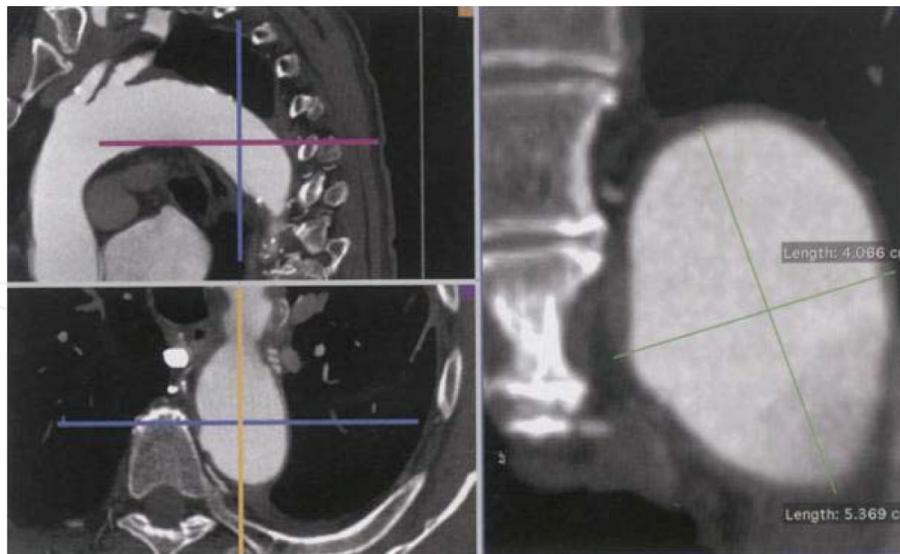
CT scan of a patient with dilated thoracic aorta. Due to the fact that the aorta follows a curved and three-dimensionally tortuous path, the axial scans are inadequate for measuring aortic diameters, as are sagittal and coronal planes for measuring aortic lengths.
